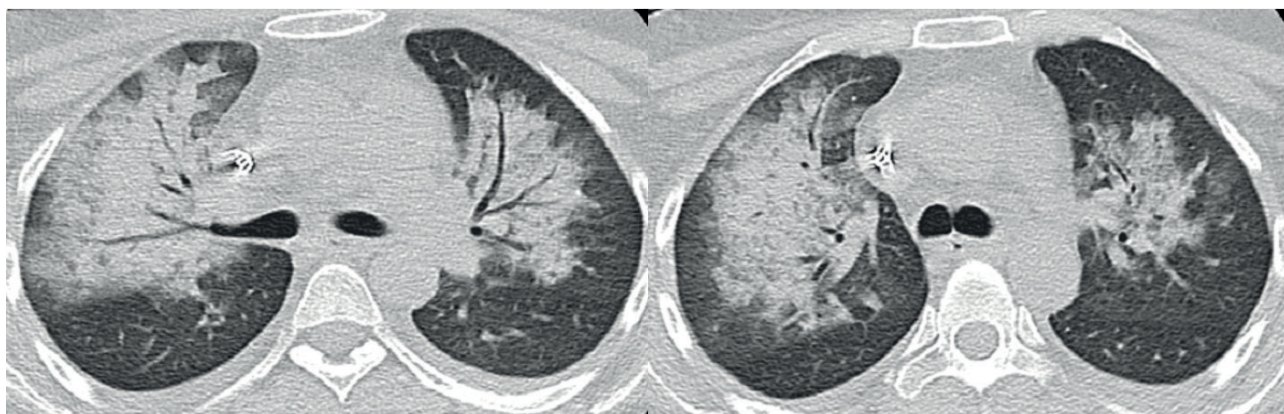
Computed tomographic images of bilateral alveolar infiltrates suggestive of diffuse alveolar hemorrhage.
